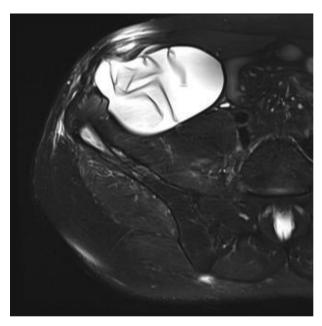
Following neoadjuvant chemotherapy a tissue expander was inserted in the right iliac fossa. This MRI taken following radiotherapy shows how the tissue expander has displaced the bowel out of the radiotherapy field. There has been dramatic shrinkage of the tumour following chemo/radio-therapy.
